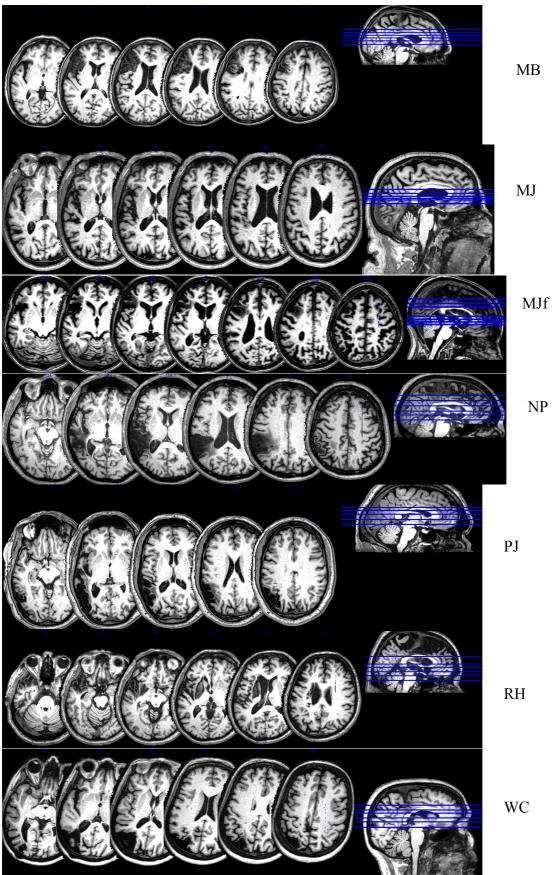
T1-weighted MRI axial slices showing lesion damage of patients (excluding GM and JL). Left side of brain is presented on left of image.
